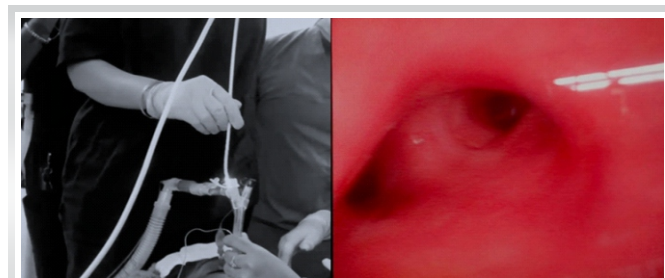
Fiberoptic confirmation of the 35 Fr DLT. Precision sizing based on USG/CT measurements ensured a perfect fit in the left main bronchus, facilitating complete lung collapse for surgical exposure.
